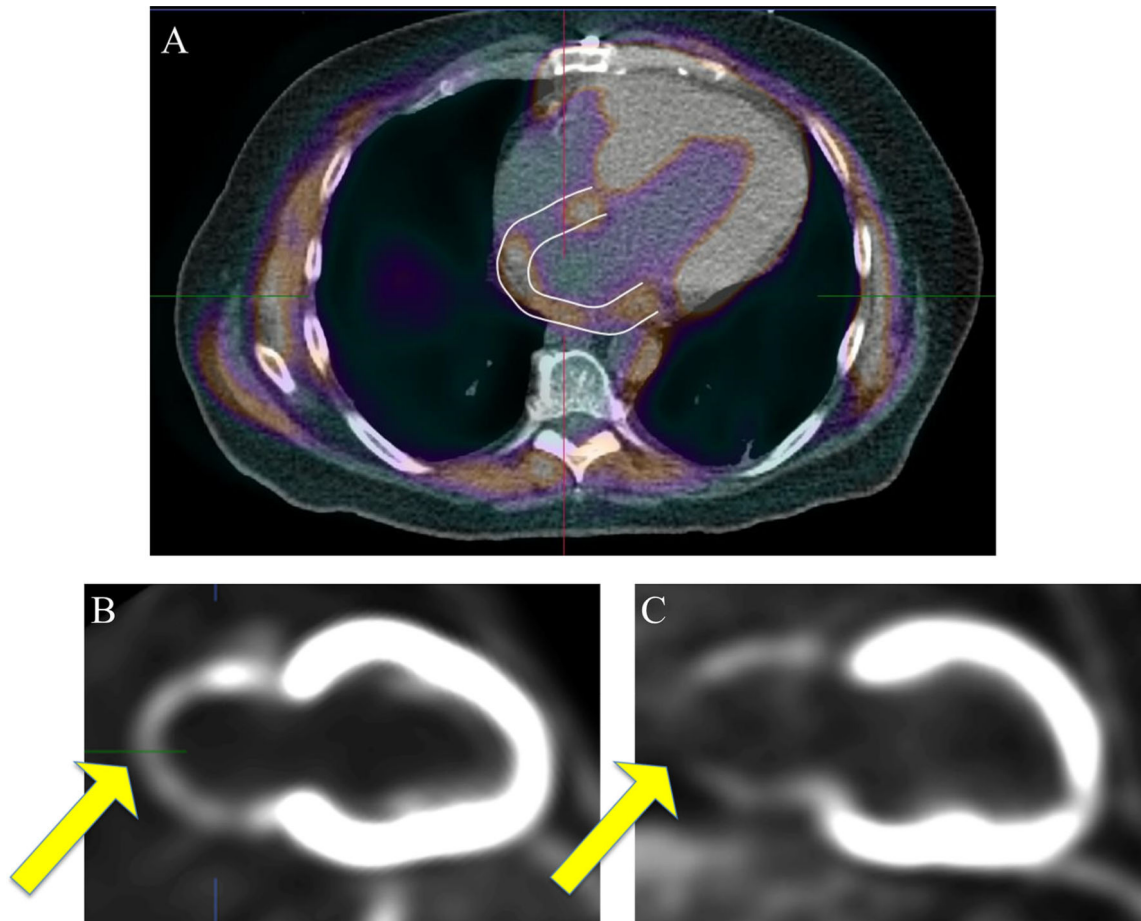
FDG PET/CT and left atrial area of interest. Integrated FDG and CT imaging with contoured region of interests excluding ventricular and extra-cardiac structure are shown in panel A. Vertical long-axis reconstructions showing nonnormalized left atrial FDG-uptake patterns are displayed in panels B and C. Panel B demonstrates relatively homogenous uptake of FDG throughout the atria compared to panel C, which demonstrates a defect consistent with hypometabolic scar. CT computed tomography. FDG, ^{18}F -fluorodeoxyglucose.
